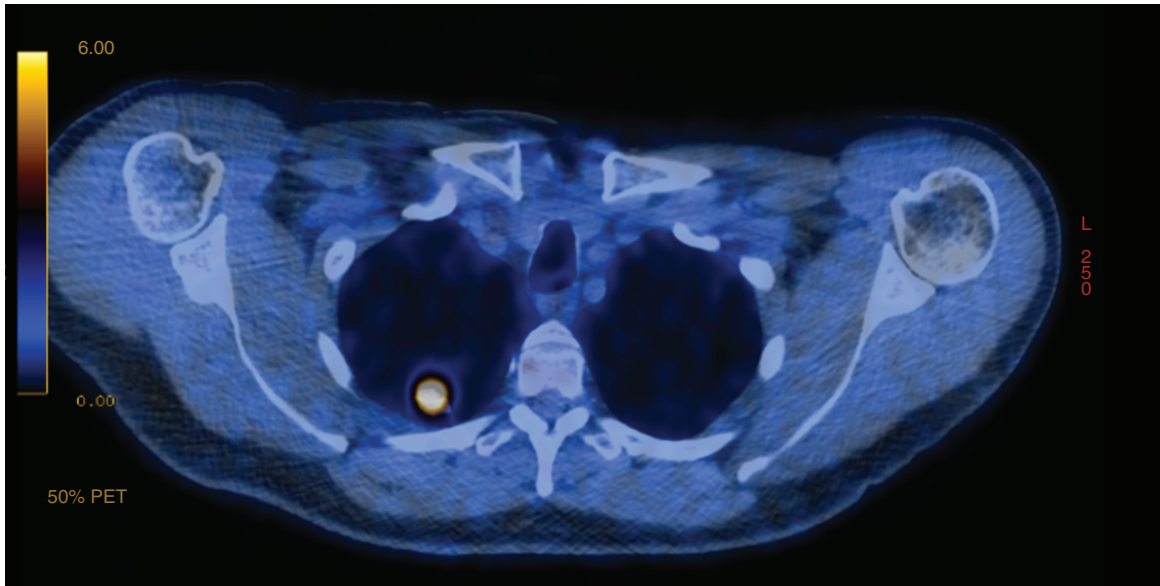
PET-computed tomography showing fluorodeoxyglucose-avidity of right upper lobe nodule shown in Figure 1 with no evidence of lymphadenopathy or metastatic disease.
